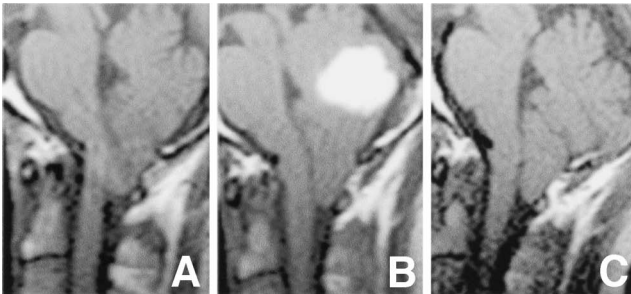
Sagittal T₁-weighted magnetic resonance images, 3 weeks before the second admission (A) showing the tip of the tonsils was 16.7 mm below the foramen magnum, 10 days after admission (B) showing the downward herniation of the tonsils had progressed to 19.2 mm, and 3 months after the second admission (C) showing the cerebellar hematoma had disappeared and the tip of the tonsils was 15.3 mm below the foramen magnum.
